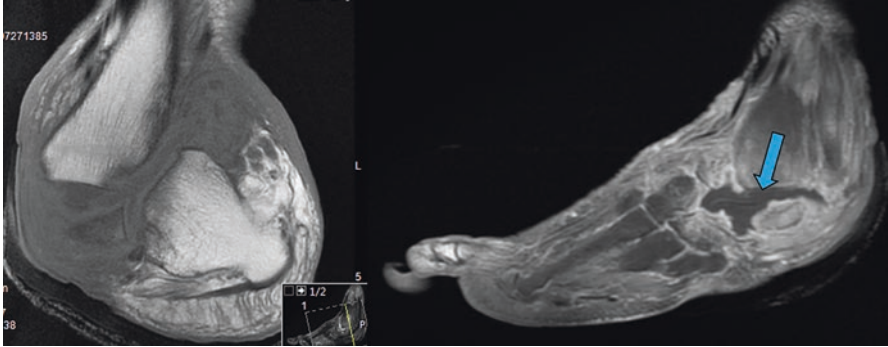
Coronal T1 MRI imaging of ankle and sagittal T1 FAT SATURATED post-contrast imaging of foot showing the degree of deformity, bone loss and fluid collection (arrow)
